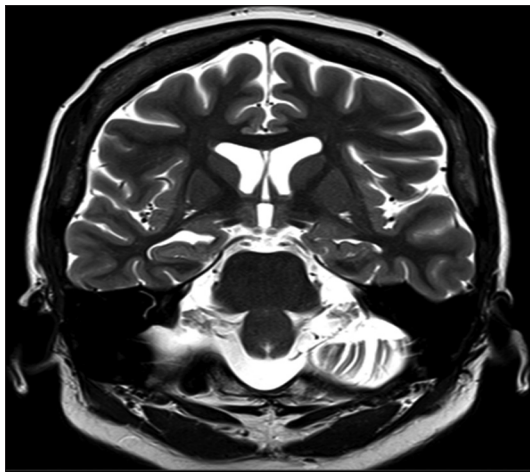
T-2 weighted MRI showing right hippocampal volume loss and a mild dilation of the right temporal horn
